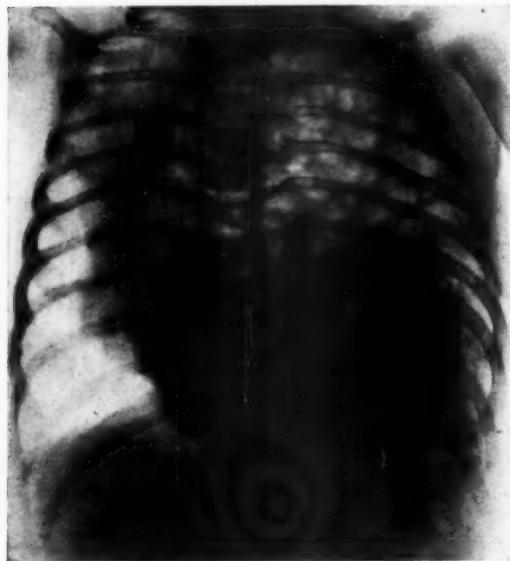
Radiograph, Case IV, showing intestines in thoracic cavity.
